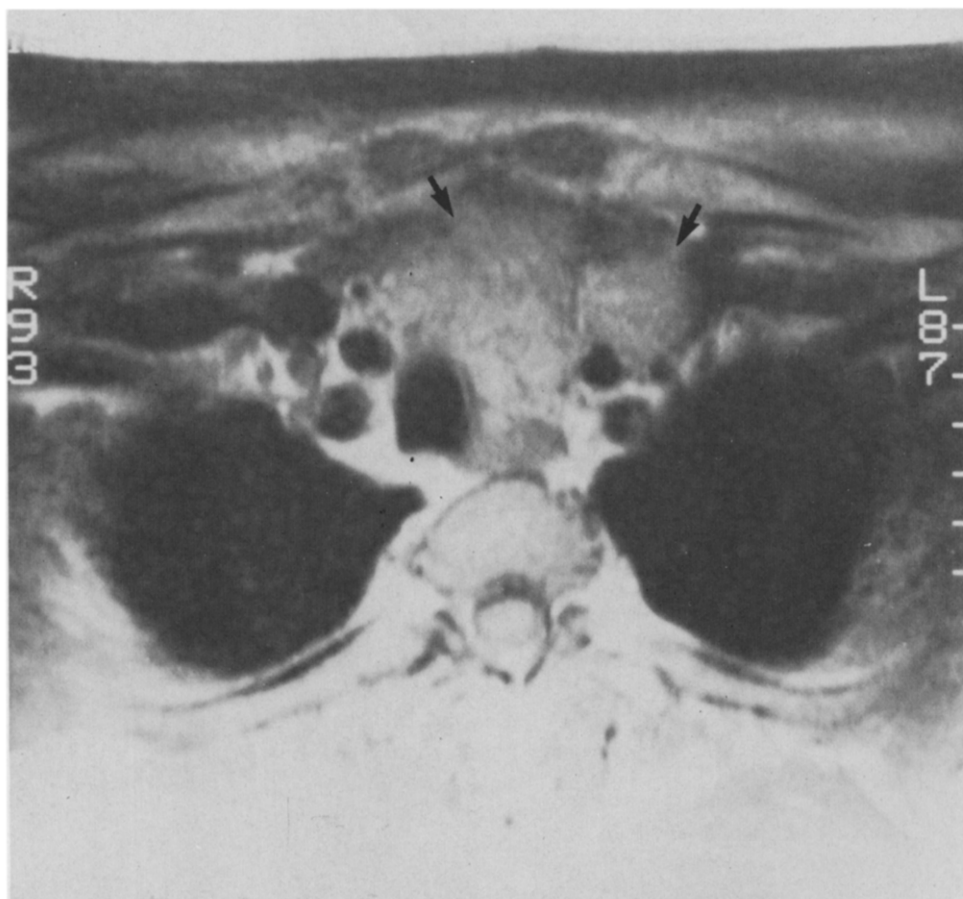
Magnetic resonance imaging (MRI) scan of a 62 year old man with recurrent follicular thyroid carcinoma with extension substernally despite two previous partial thyroid resections and 100 millicuries of radioactive iodine (arrows delineate anterior extension of tumor).
